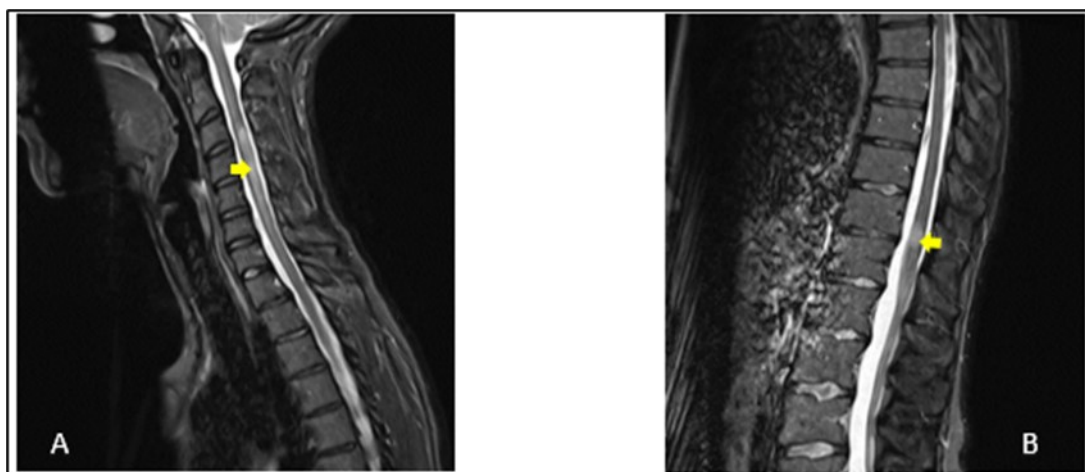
Sagittal T2-weighted spine MRI showing at cervical level (A), a spontaneous hyperintense lesion of 5 cm from C3 to C6 and at thoracic level (B), a spontaneous hyperintense lesion of 1.5 cm from T11-T12
